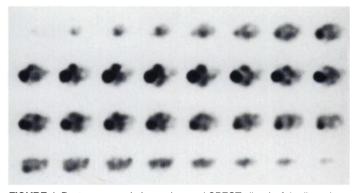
Postmortem scintigram (coronal SPECT slices) of the liver show multiple lesions with [¹³¹][MIBG uptake.
